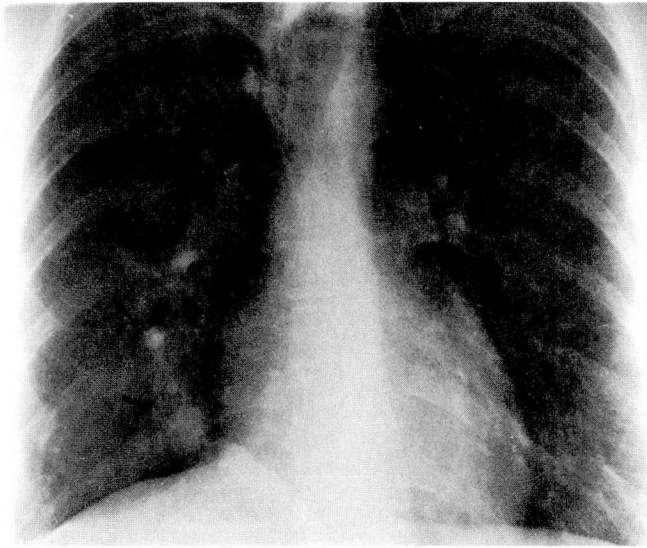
Case 1. Preoperative chest radiograph demonstrates the scimitar sign.
